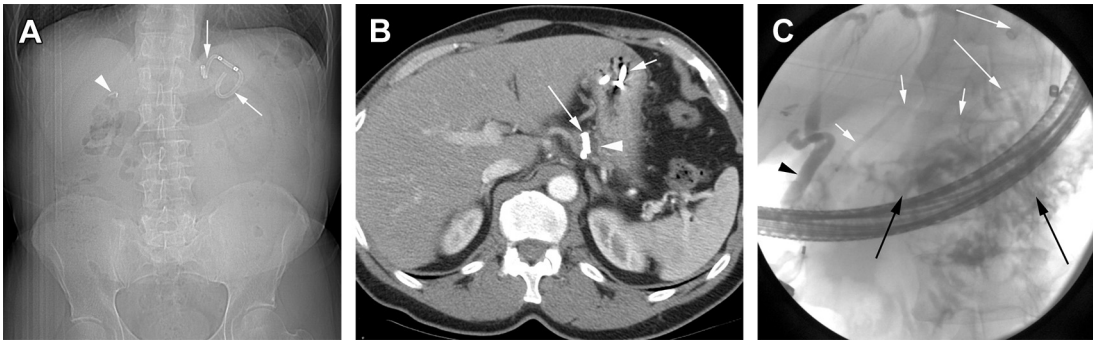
Cystogastrostomy for a large pseudocyst. (A) This 40-year-old man with early satiety and discomfort from a large pseudocyst underwent an endoscopically placed cystogastrostomy. The scout view demonstrates the stent (arrows) with the superior coil in the stomach and the inferior coil in the pseudocyst. Surgical cholecystectomy clips (arrowhead) also are present. (B) Same patient as Fig. 14A. The axial CT image reveals the stent (long arrow) in the pseudocyst, which shows only a small residual fluid collection (arrowhead) following successful drainage. The portion of the stent located in the stomach (short white arrows) also is seen. (C) Endoscopic retrograde cholangiopancreatography (ERCP) in the same patient as Fig. 14A. The ERCP demonstrates filling of the pancreatic duct (short white arrows) without filling of a fluid collection, but communication with the stomach (black arrows) is readily identified demonstrating that the stent (long white arrows) is open. The common bile duct (black arrowhead) also is filled with contrast.
